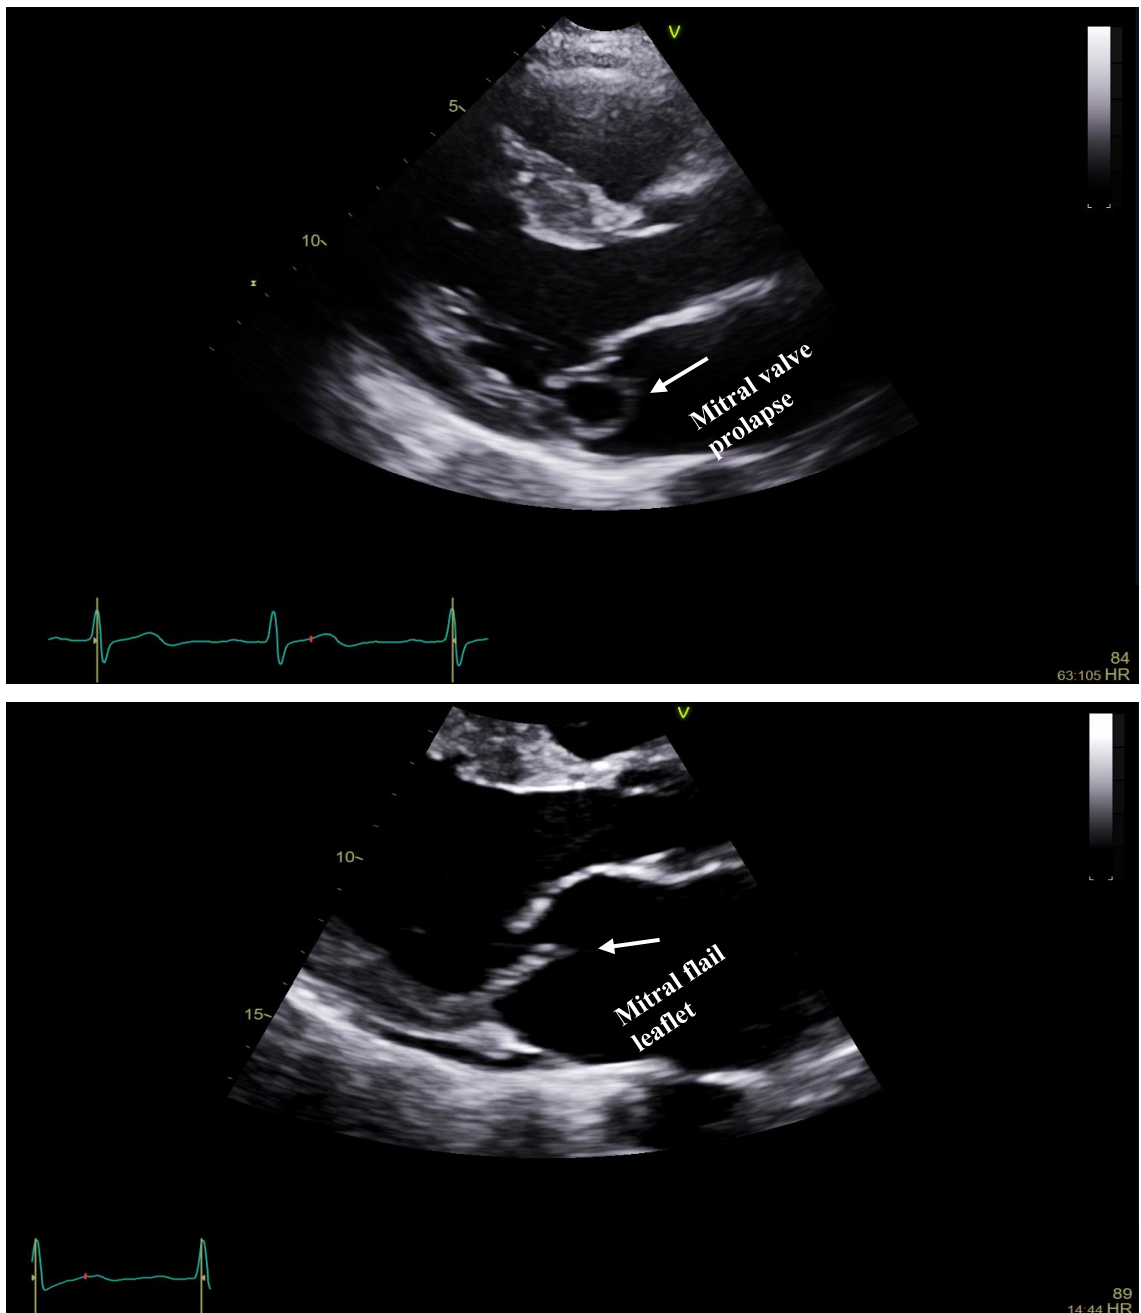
Parasternal long axis view showing mitral valve prolapse with coaptation line below the annular plane- top, and flail leaflet with leaflet tip is completely reversed toward the left atrium- bottom.
